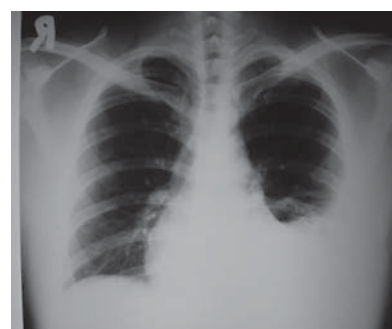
Plain chest radiograph with increased opacity along the left lower hemithorax and blunting of the costophrenic angle.
